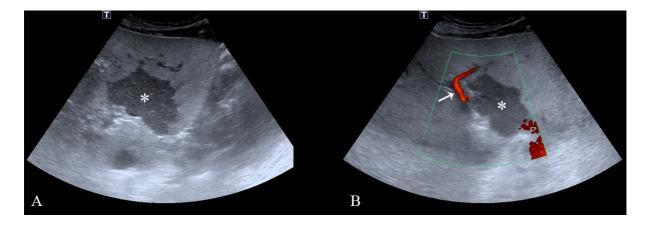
CASE 2. The initial ultrasound images required further CT evaluation. A - hypoechoic fat sparing area (*) located within the II^{nd}/III^{rd} segments. B – Doppler images showing no vascularization of the (pseudo)lesion (*) and no other vessel derived from the left branch of the portal vein (*arrow*).
